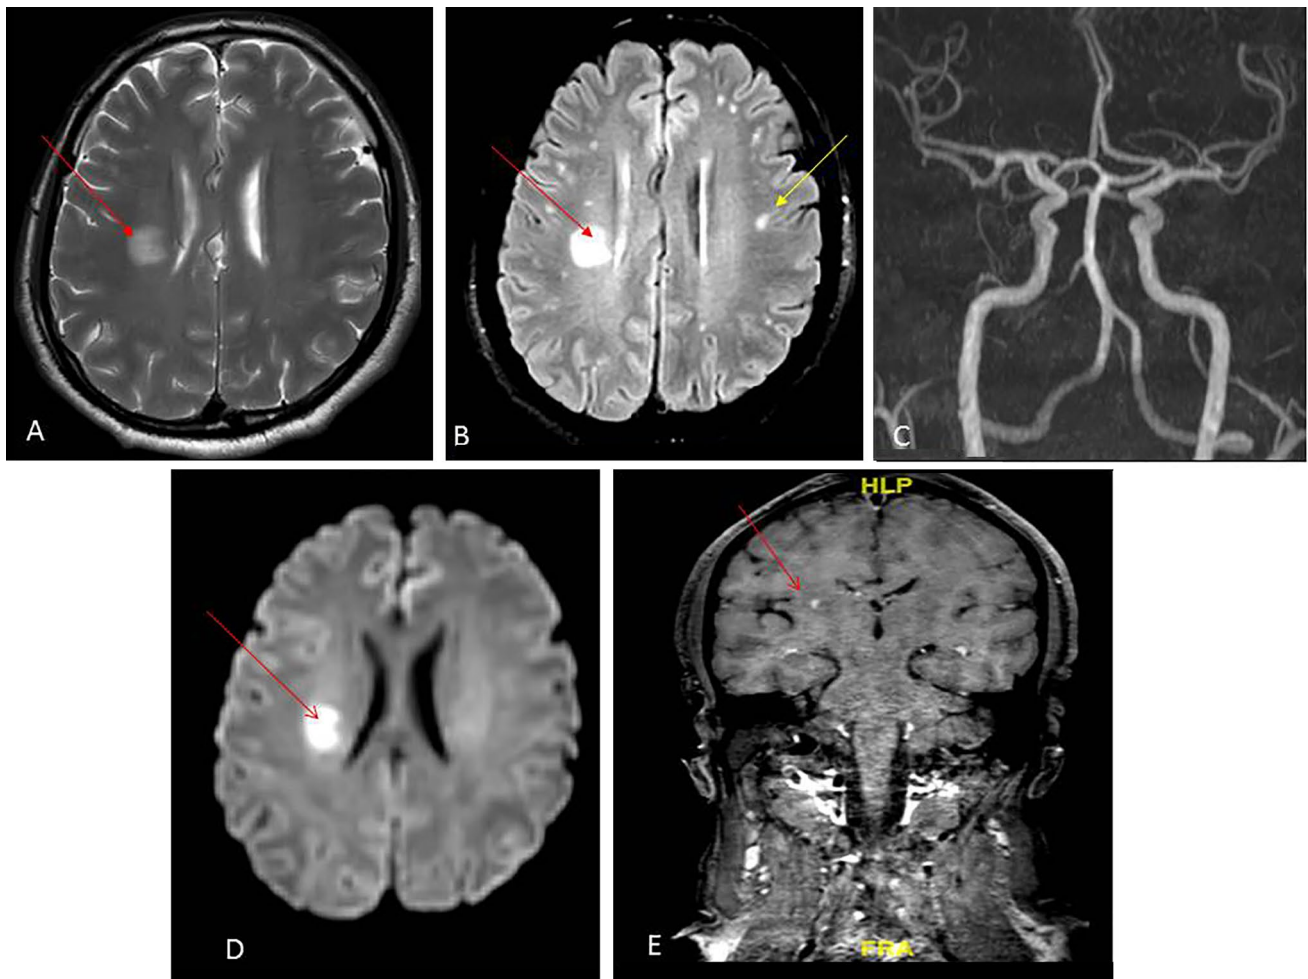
Brain MRI T2 axial image A showing hyperintense lesion in right corona radiata (red arrow); B axial fluid-attenuated inversion recovery (FLAIR) image showing hyperintense lesion in right corona radiata (red arrow) with multiple small subcortical hyperintense
